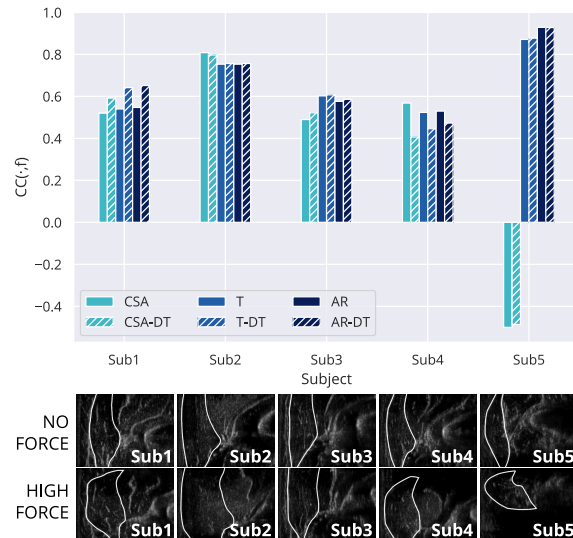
Top*: Correlation of cross-sectional area (CSA, cyan), thickness (T, blue) and aspect ratio (AR, dark blue) of the brachioradialis cross section, both raw (solid) and detrended (hashed), with elbow output force, across various subjects, collected at ~69° elbow flexion. CSA, T, and AR deformation signals, especially when detrended, correlate well with output force, though the magnitude and direction of these correlations varies widely across subjects. *Bottom*: Example ultrasound frames with annotated brachioradialis contours depicting no force (top row) and high output force (bottom row) for each subject reflect substantial morphological variation.
